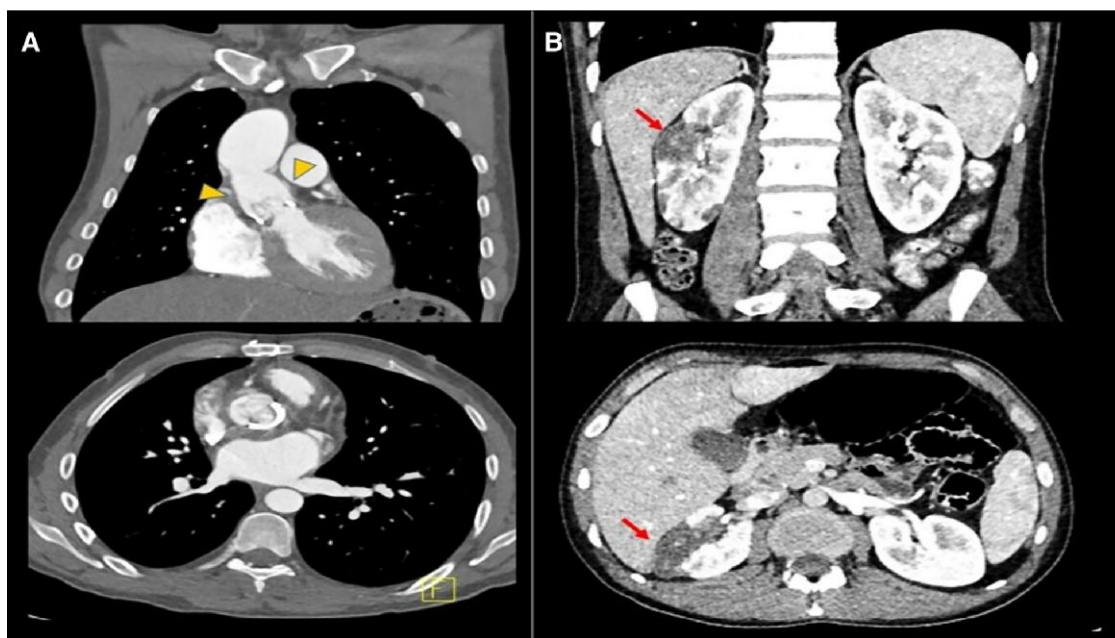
Computed tomography angiography. (A) Ascending aorta with post-surgical changes by Bentall–De Bono with biological prosthesis and woven Dacron graft, associated with hyperdense surgical material (triangles). There's no evidence of suggestive findings of mediastinitis, collections, or infectious process. (B) Right kidney with suggestive images of infarctions (red arrows).
